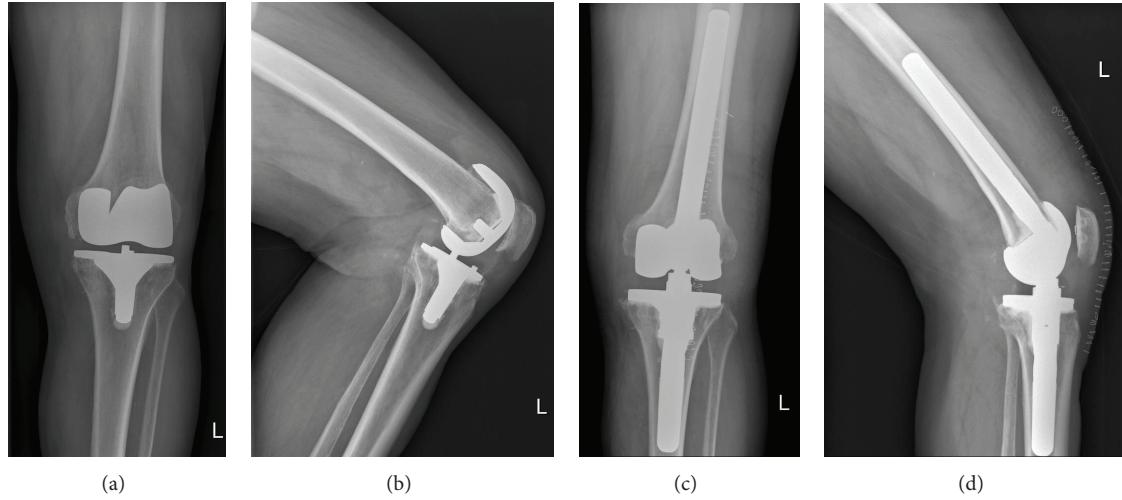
(a) Radiographs of aseptic loosened TKA in 77-year-old male—ap view. (b) Radiographs of aseptic loosened TKA in 77-year-old male—lateral view. (c) Postoperative X-rays after one stage revision with EnduRo RHK—ap view. (d) Postoperative X-rays after one stage revision with EnduRo RHK—lateral view.
